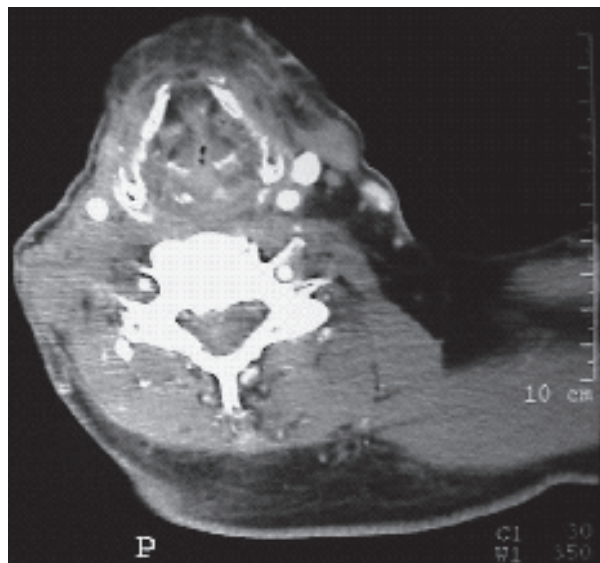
CT of the neck demonstrates the marked narrowing of the airway in the area of the larynx but no definite soft-tissue abnormality. These findings are consistent with mucosal edema.
